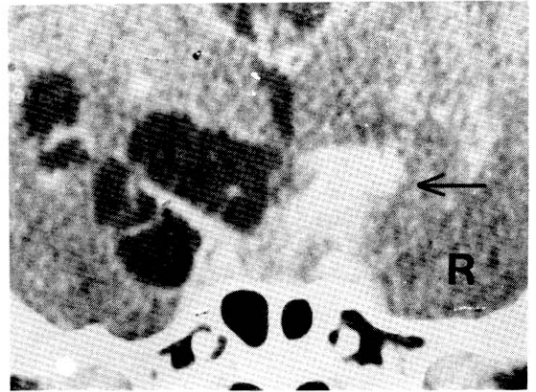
Coronal CT scan of the sella after intrathecal injection of metrizamide. Contrast filling in the right side of the suprasellar cistern (arrow) and the pituitary fossa is differentiated with cystic lesions in the left sylvian area, which is revealed in neurocysticercosis.
